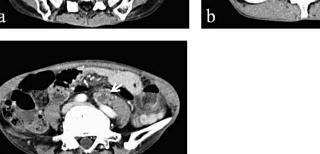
Computed tomography revealed a solid mass in the sigmoid colon (a) and a hydroureteronephrosis (b) due to swelling of a mesenteric lymph node (c).
